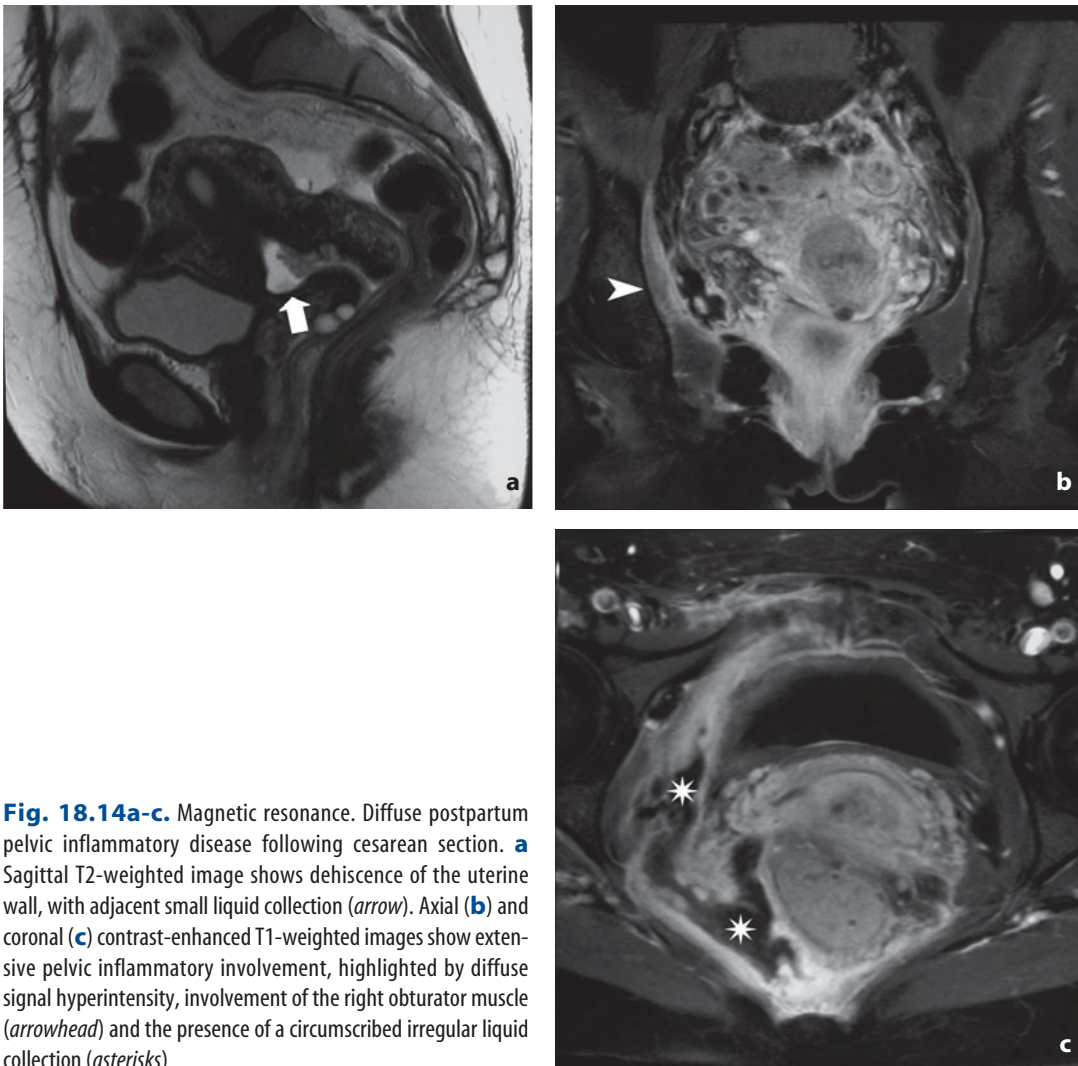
Magnetic resonance. Diffuse postpartum pelvic inflammatory disease following cesarean section. a Sagittal T2-weighted image shows dehiscence of the uterine wall, with adjacent small liquid collection (*arrow*). Axial (b) and coronal (c) contrast-enhanced T1-weighted images show extensive pelvic inflammatory involvement, highlighted by diffuse signal hyperintensity, involvement of the right obturator muscle (*arrowhead*) and the presence of a circumscribed irregular liquid collection (*asterisks*)
